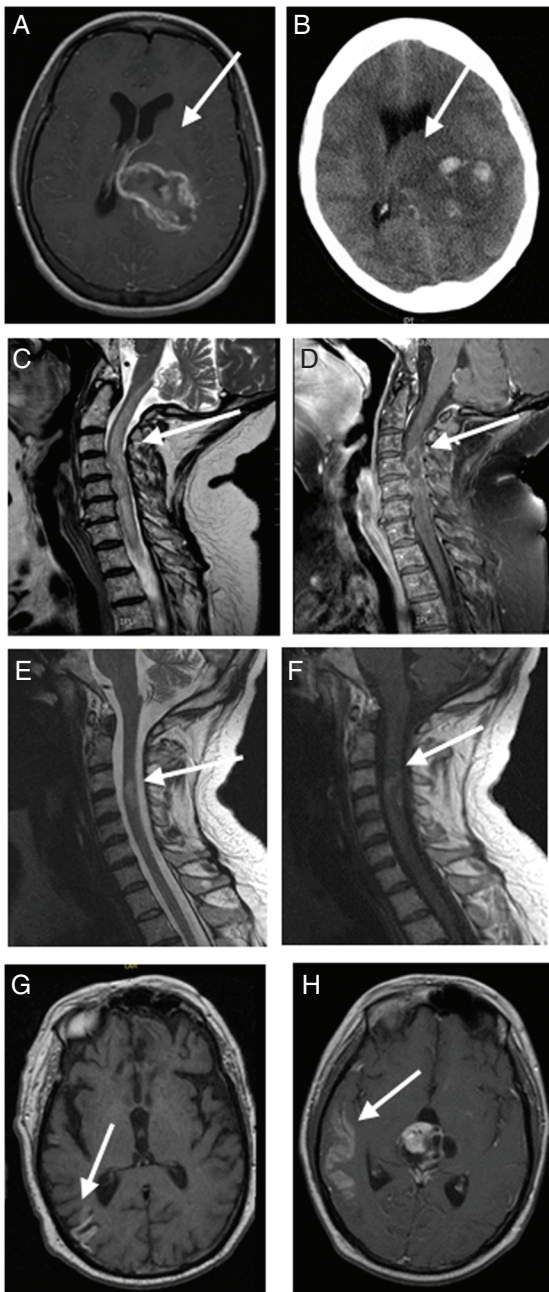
Representative images of rare adverse events. (A and B, case 1) Cerebral edema. 32 y/o female with a large left-sided thalamic grade III astrocytoma experienced neurological decline after first IA treatment. (A) Preprocedural axial T1-weighted post gadolinium MRI shows large tumor and associated edema (B) Postprocedural noncontrast CT head shows worsening edema with midline shift. (C and D, case 2) Cervical cord injury. Case 2. 59 y/o female with PCNSL experienced cervical cord injury after sixth treatment (LVA injection). (C) Sagittal T2-weighted MRI shows cervical stenosis and T2 cervical cord signal. (D) Sagittal T1-weighted MRI shows postcontrast enhancement of the involved region. (E and F) 39 y/o male with grade III oligodendroglioma experienced cervical cord injury after fourth treatment (RVA injection). (E) Sagittal T2-weighted MRI demonstrates a similar cervical cord injury with capacious spinal canal. (F) Sagittal T1-weighted post gadolinium
